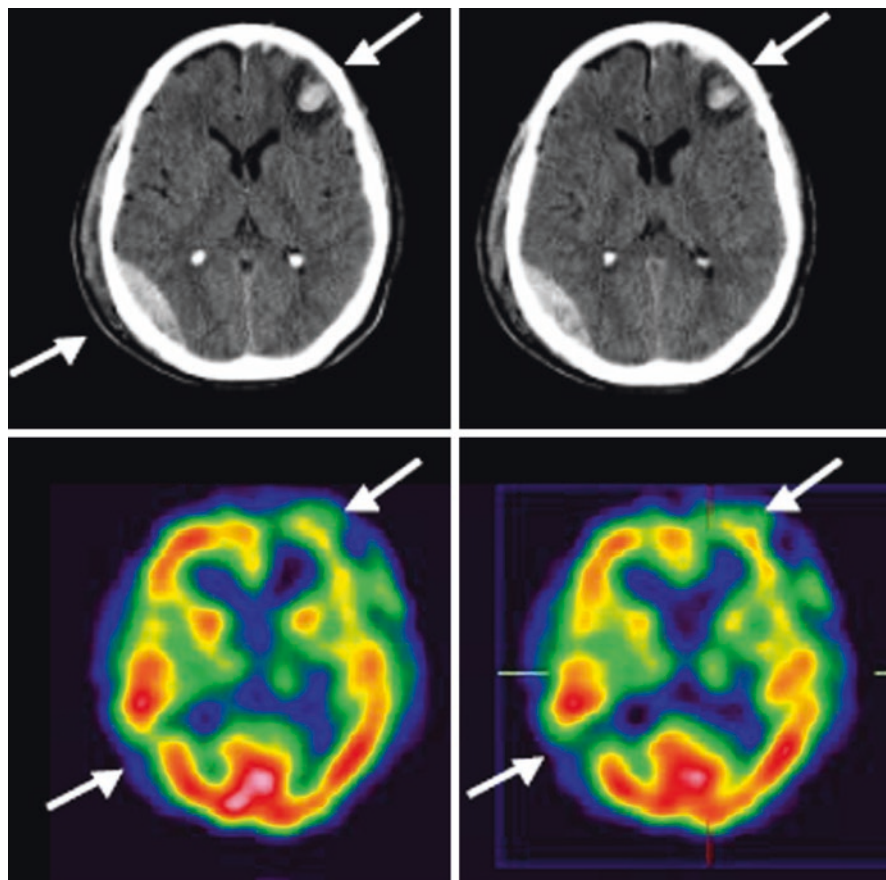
CT and SPECT perfusion imaging of a patient with left frontal primarily brain trauma. In the hemorrhagic lesion seen on the CT in the right posterior temporal region, SPECT images show an absence of perfusion. (From Pifarré et al. (2011))
